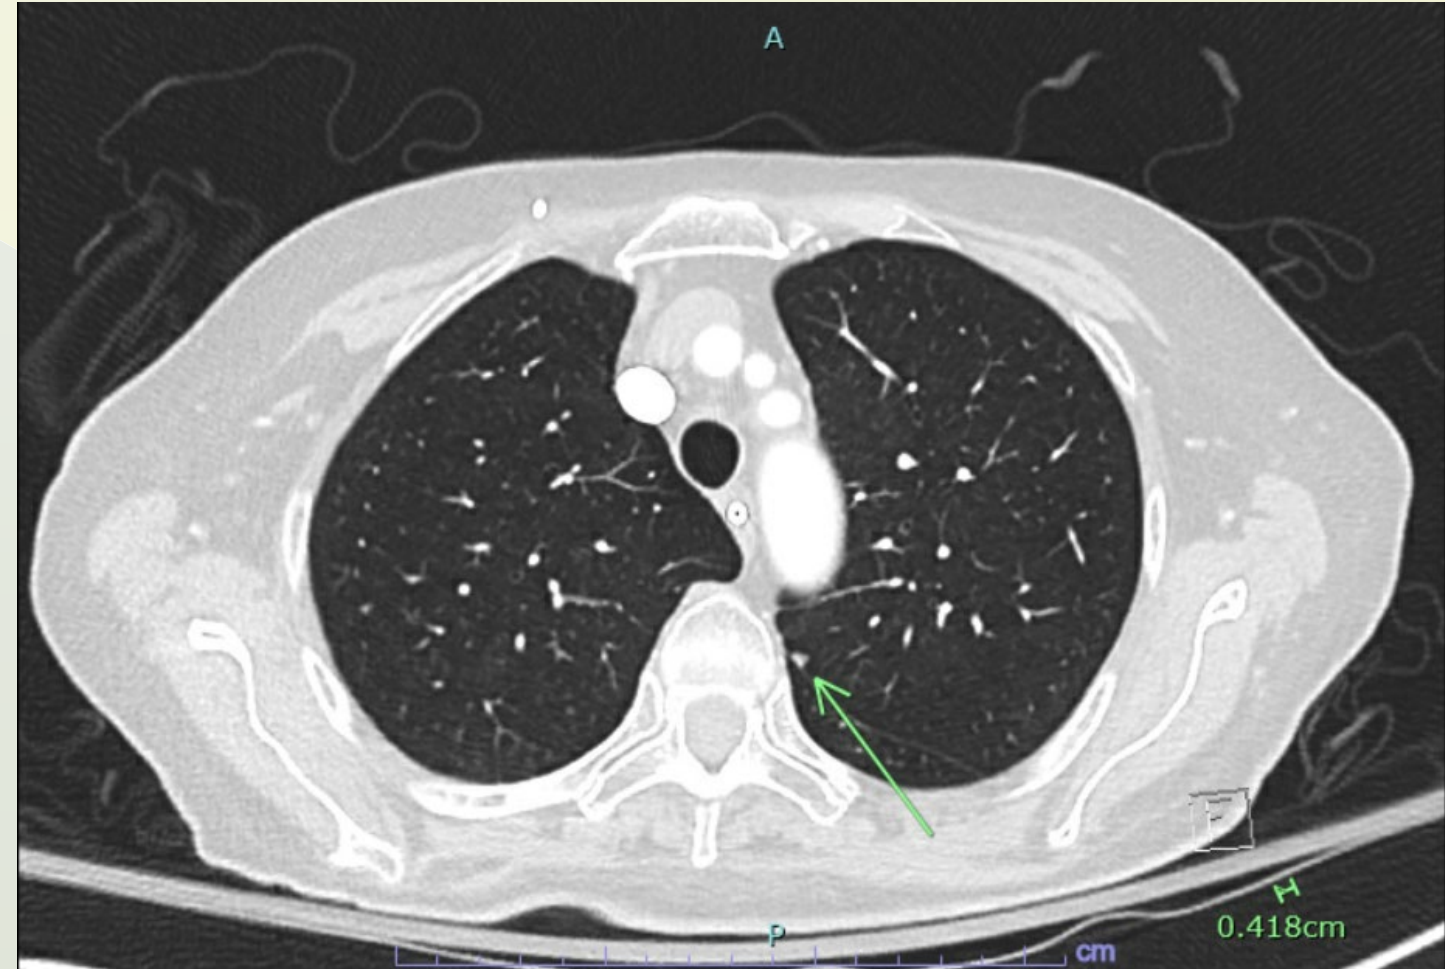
Chest CT without contrast
